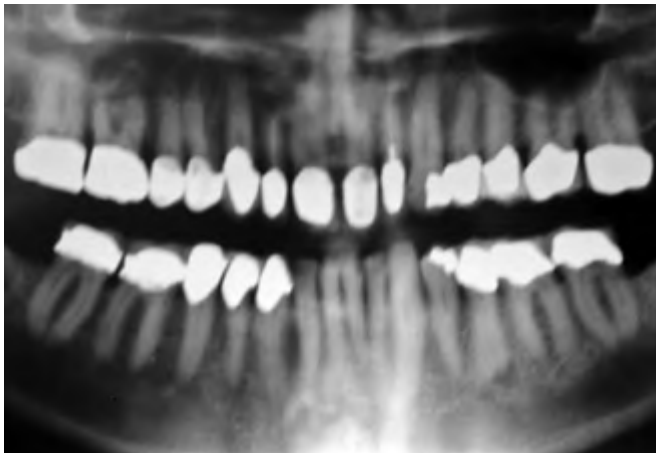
The original panoramic radiograph prior to the extraction of the maxillary right lateral incisor.
